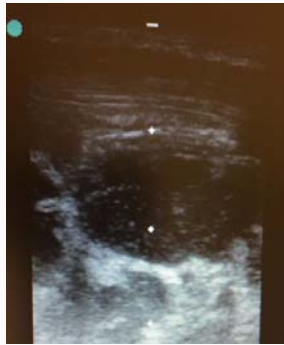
Bedside Ultrasound with Visualized Fluid Collection.
